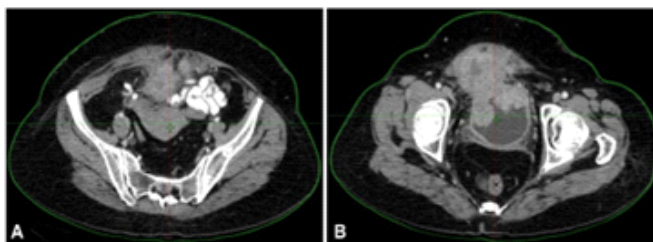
CT Images Demonstrating Progression of the Pelvic Mass Following Initial Chemotherapy
